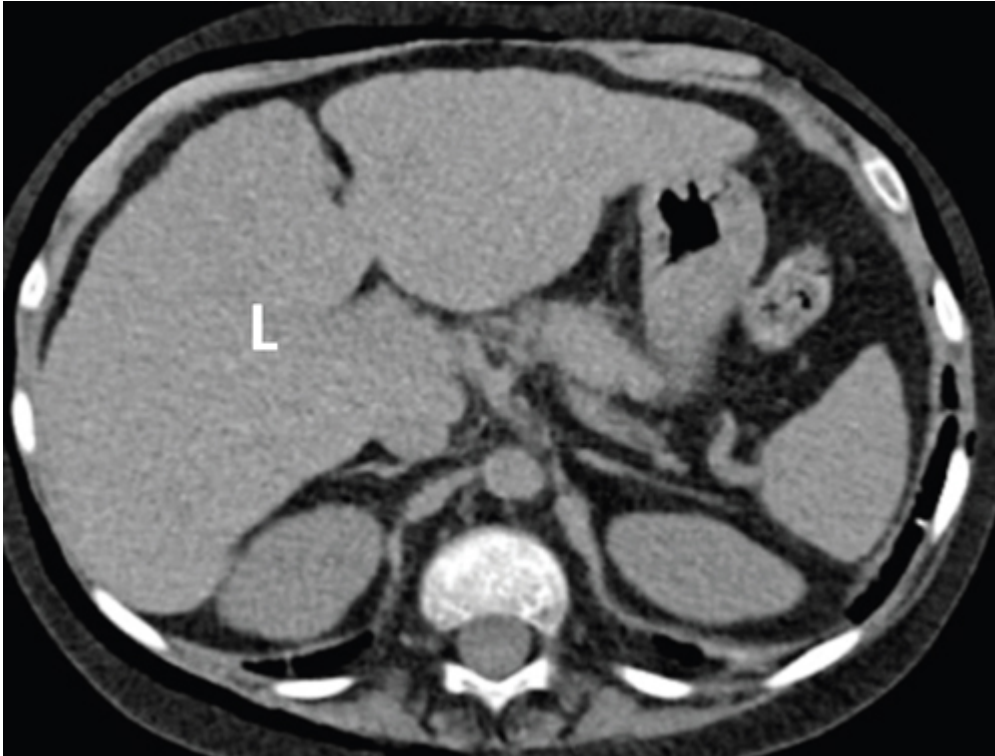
CT scan showed contour irregularity and slight heterogeneity of the liver (L).
